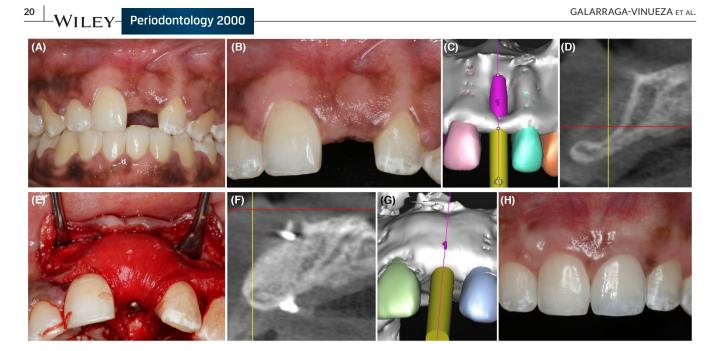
Horizontal bone augmentation with freeze-dried bone allograft (FDBA) and rhPDGF-BB. (A, B) Clinical view at baseline. (C) Digital implant planning visualizing the buccal bone deficiency. (D) Cone beam computed tomography scan. (E) A staged guided bone regeneration with FDBA soaked with rhPDGF-BB was performed. A collagen barrier membrane was stabilized on the palatal and buccal aspects on top of the bone allograft. (F) Cone beam computed tomography scan obtained 6 months after the augmentation procedure. (G) Digital planning for implant therapy. (H) Final outcome of implant rehabilitation at 1 year.
